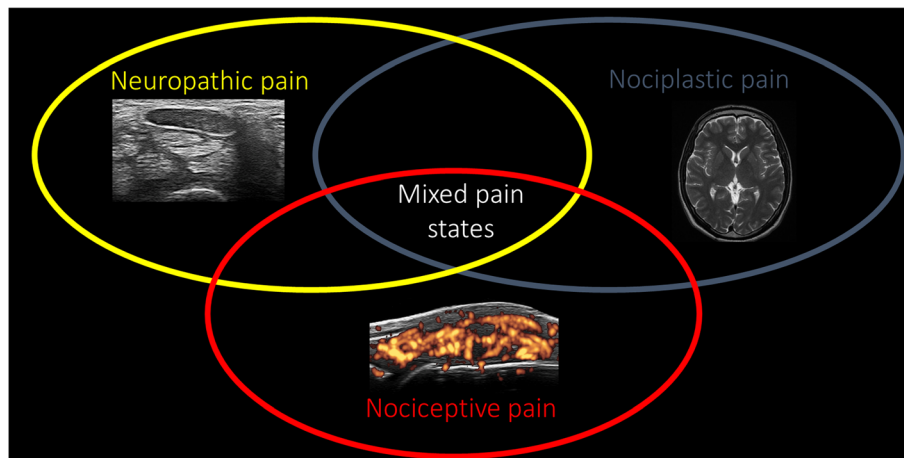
Pain mechanisms in patients with chronic inflammatory joint diseases. Three pathophysiological mechanisms of pain frequently coexisting in patients with chronic inflammatory joint diseases. The red circle contains the nociceptive mechanisms, represented in the figure by the ultrasound image of an active synovitis of a metacarpophalangeal joint in a subject with rheumatoid arthritis. The neuropathic mechanisms are enclosed with yellow circle, in this case documented by the ultrasound image of a median nerve markedly enlarged at the inlet of the carpal canal, indicative of a carpal tunnel syndrome in a subject with rheumatoid arthritis. In the gray circle, the nociplastic mechanisms of pain centralization are exemplified in case of concomitant fibromyalgia, magnetic resonance image of a morphologically normal brain.
